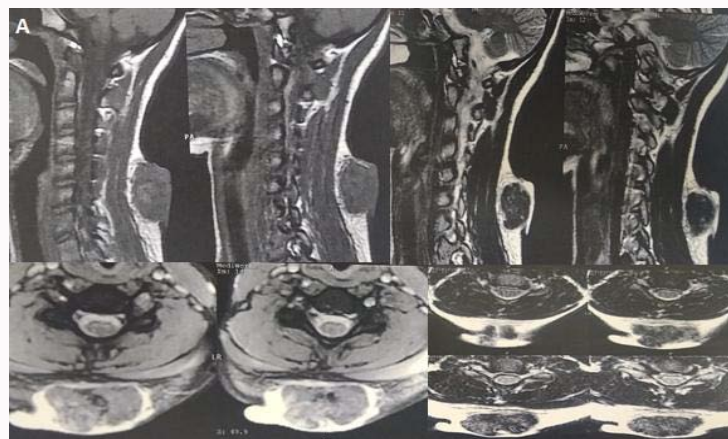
MRI showing that the lesion is restrict to the skin.
